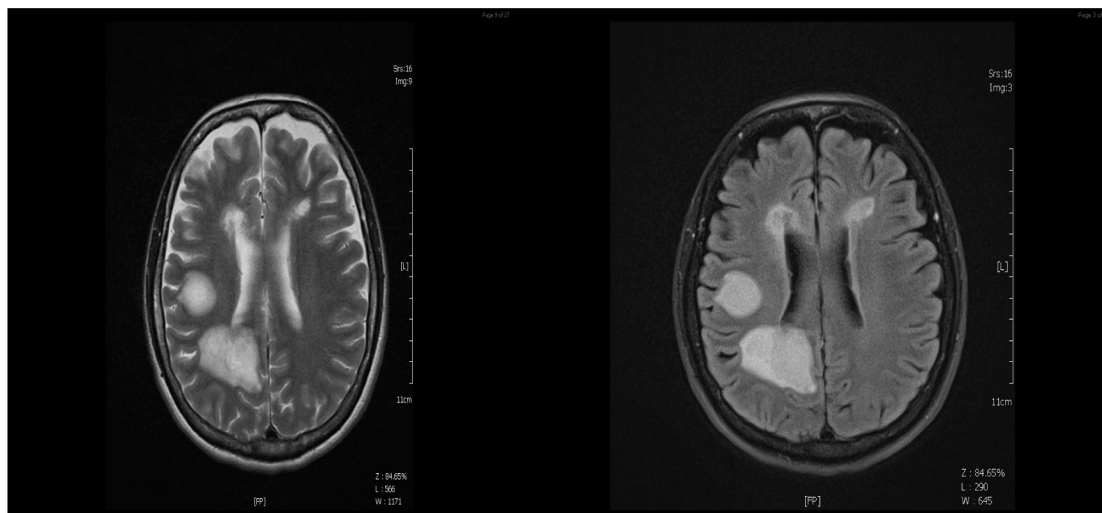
Brain MRI showed extensive multifocal asymmetrical T2 hyperintensities in the subcortical and periventricular white matter. Please note simultaneous enhancement of all the cerebral lesions on T1-weighted postgadolinium image.
